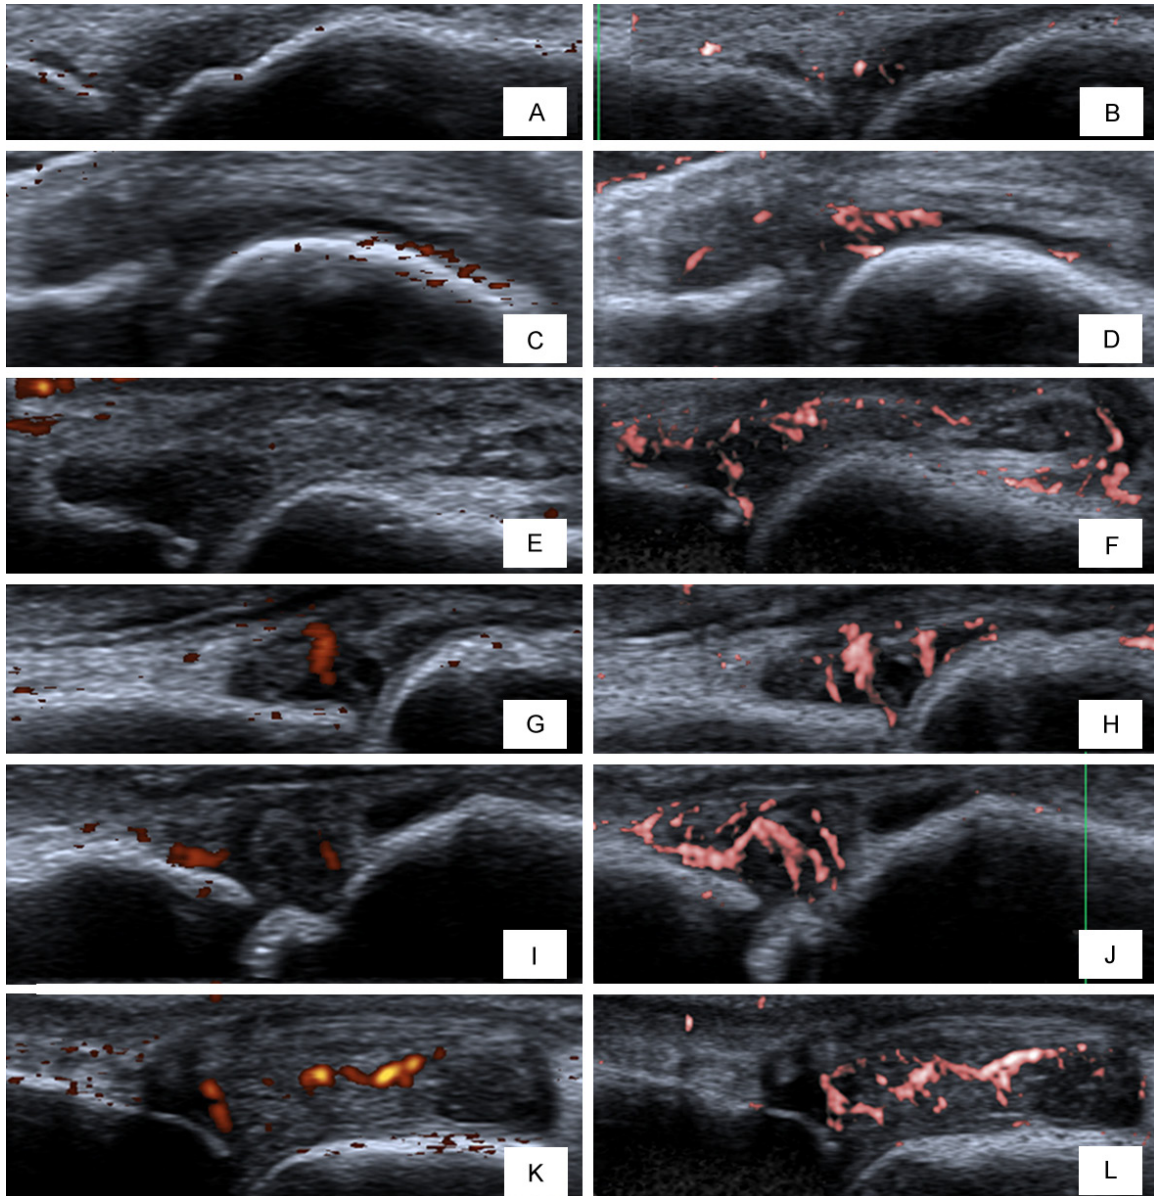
The flow signals in PDUS and SMI. A and B: Longitudinal sonograms of the right second metacarpophalangeal joint. A: Grade 0 in PDUS, B: Grade 1 in SMI. C and D: Longitudinal sonograms of the right third metacarpophalangeal joint. C: Grade 0 in PDUS, D: Grade 2 in SMI. E and F: Longitudinal sonograms of the left second metacarpophalangeal joint. E: Grade 0 in PDUS, F: Grade 3 in SMI. G and H: Longitudinal sonograms of the right third metacarpophalangeal joint. G: Grade 1 in PDUS, H: Grade 2 in SMI. I and J: Longitudinal sonograms of the right second metacarpophalangeal joint. I: Grade 1 in PDUS, J: Grade 3 in SMI. K and L: Longitudinal sonograms of the right second metacarpophalangeal joint. K: Grade 2 in PDUS, L: Grade 3 in SMI.
